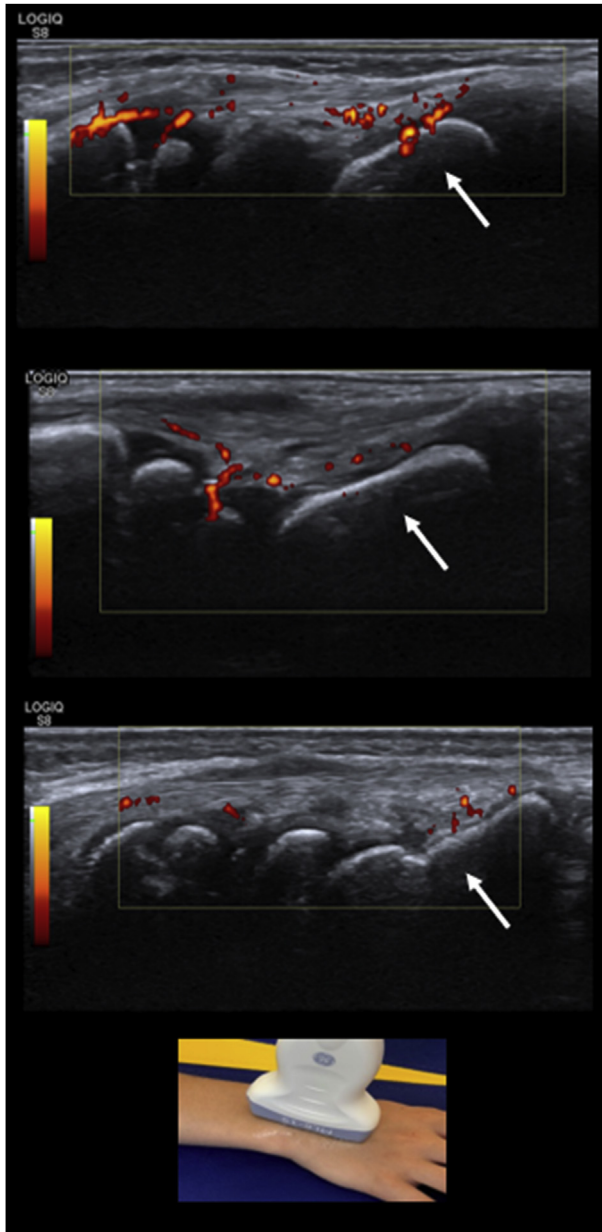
Development of the wrist on ultrasound. US images showing the cartilaginous midhand in the dorsal longitudinal scan with physiologic feeding vessels from toddlers (upper image) to adolescent age (lower image). Ossification and growth of os capitate (arrows).
